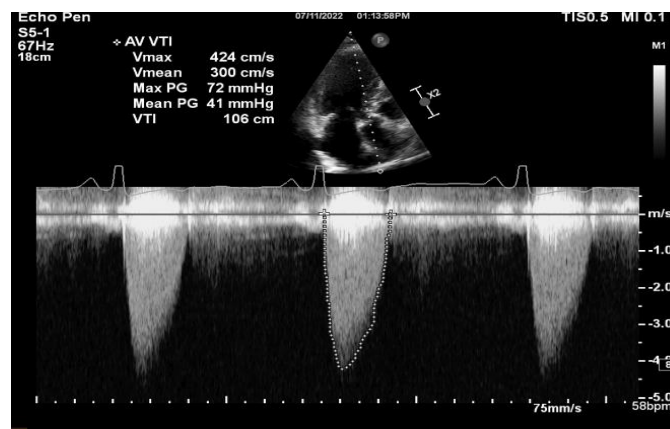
Continuous wave Doppler across LVOT on apical 3-chamber view on transthoracic echocardiogram. Doppler measurements are consistent with severe aortic valve stenosis, with early-peaking morphology. Dynamic LVOT obstruction in hypertrophic cardiomyopathy would have a late-peaking (“dagger shape”) morphology.
